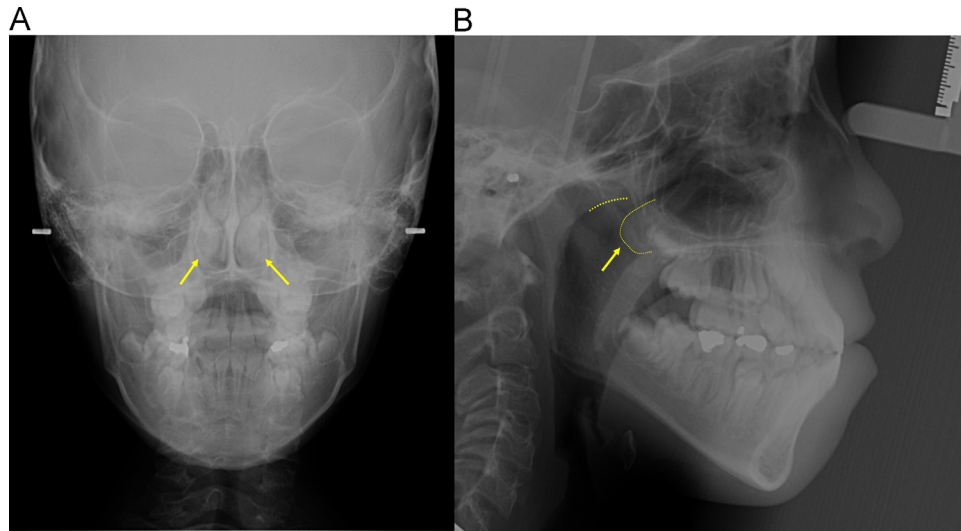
(A) Bilateral obstruction of the airway, in a 9-year, 4-month-old patient, by the hypertrophied inferior turbinates (right and left arrows) shown on a postero-anterior cephalograph. (B) The patient's lateral cephalometric radiograph shows the posterior extension of the inferior turbinate toward the posterior wall of the nasopharynx (arrow). This hypertrophy induced a narrowing of the airways and shift to mouth breathing mode.
